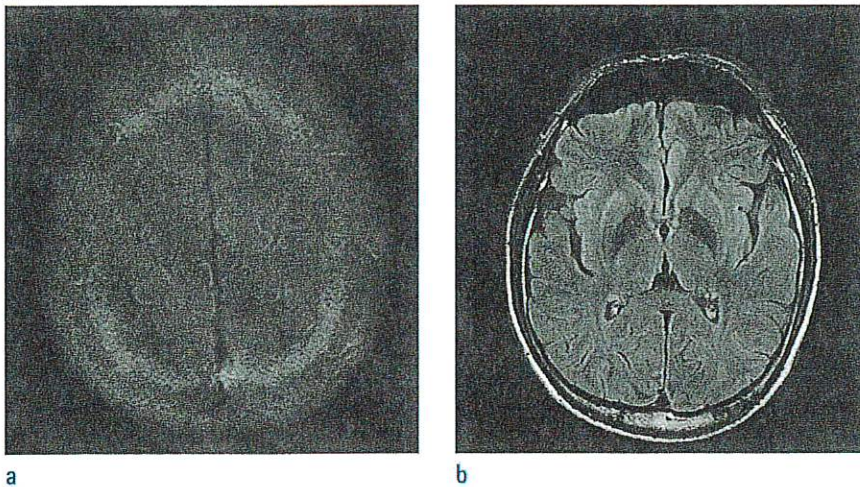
Follow-up MRI (ten days later), FLAIR image shows curvilinear high signal intensity in the bilateral frontal and bilateral basal ganglia. FLAIR = fluid-attenuated inversion recovery
